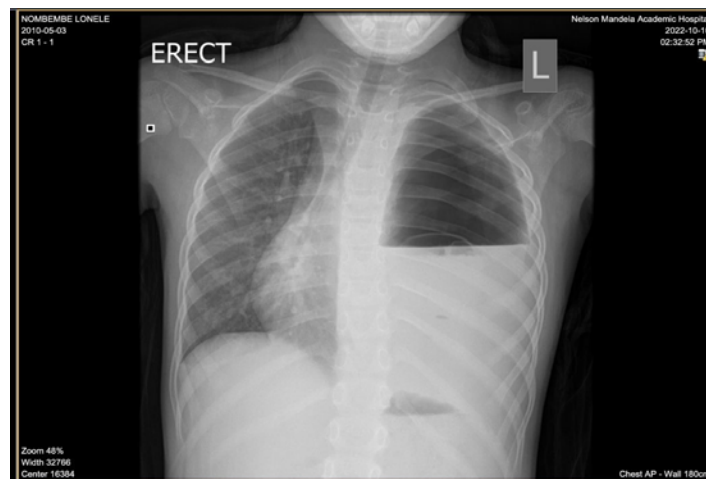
Chest X-ray of a 7 years old child, male, showing a hydatid cyst in the left lung with air inside due to bronchial communication.
